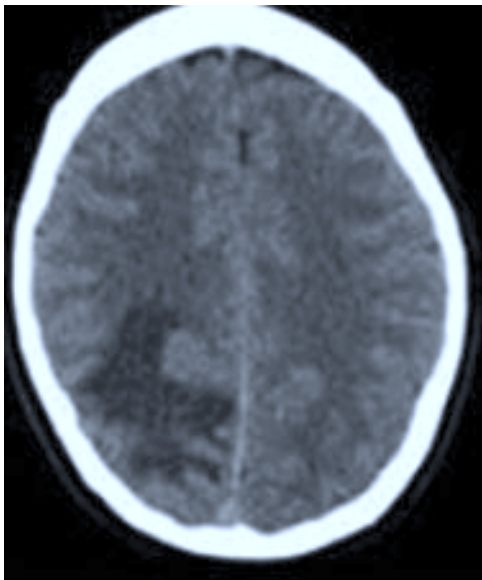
CT Scan of Brain
